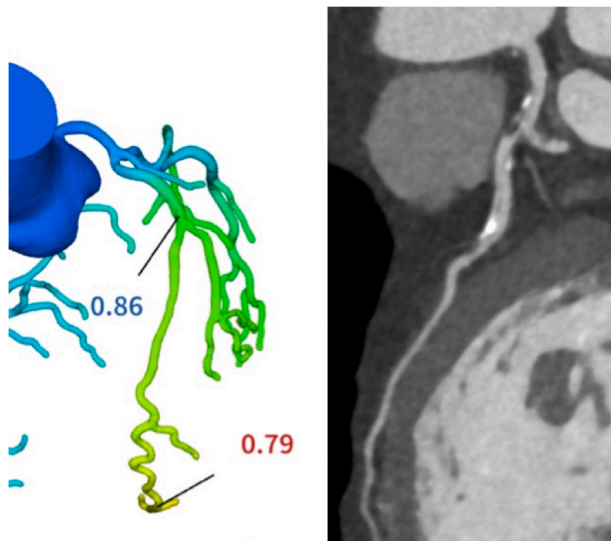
CAD RADS 3/P3/I+-. A moderate (50–70% diameter stenosis (DS)) ostial left anterior descending (LAD) stenosis. The post stenosis CT-FFR at 2cm distal to the stenosis is 0.86 in keeping with no lesion specific flow limitation. There is further mild (25–49% DS) mid vessel stenosis. While there is a borderline distal vessel positivity (0.79) there is no acute drop-off in CT-FFR associated with the mid vessel stenosis. This diffuse disease was not considered to derive benefit from percutaneous intervention and was managed with optimal medical therapy.
